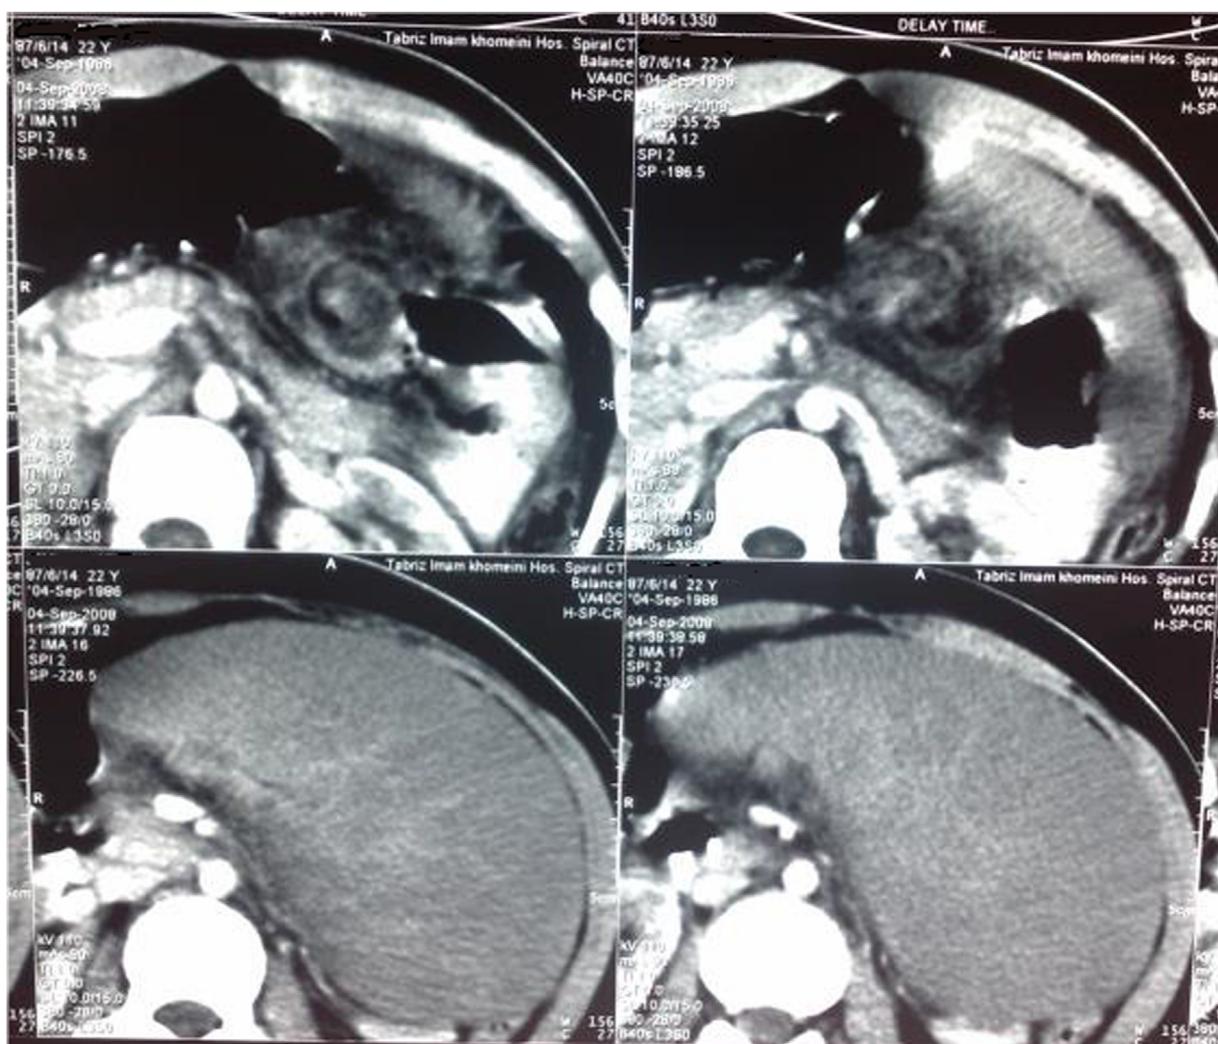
Contrast-enhanced CT scan of the abdomen showing a congested spleen with a pedicle torsion and its hilum pointing toward the left lateral. Ring enhancement of the spleen capsule, weak enhancement of the spleen parenchyma, and cork screw-like soft tissue density containing enhanced splenic vessels suggesting a distorted splenic pedicle, is presented.
